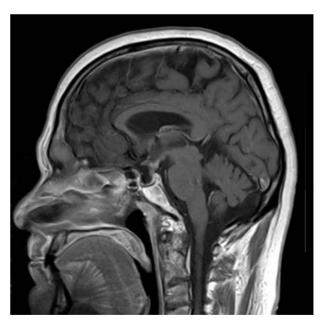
Brain magnetic resonance image: on the sagittal post contrast T1 weighted image, abnormally thickened pituitary stalk is confirmed, with very tiny hypophysis pushed down and posteriorly by a mild suprasellar cerebrospinal fluid herniation.
